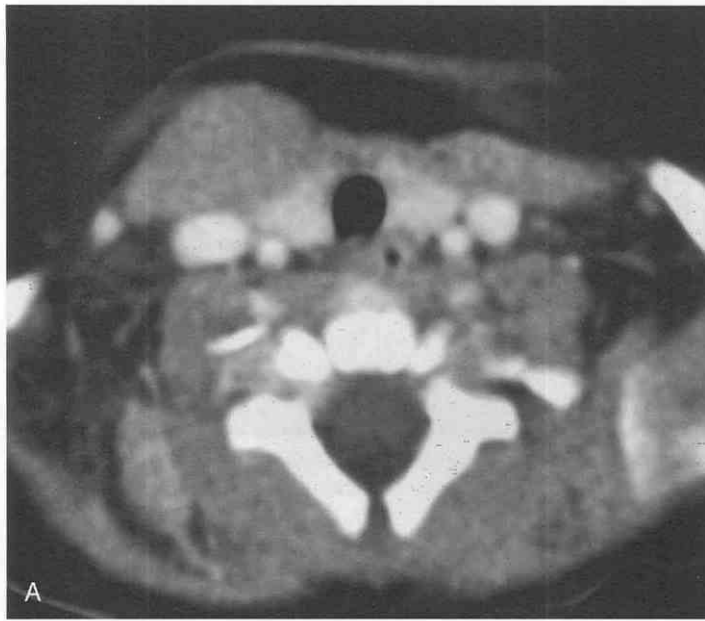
Fibromatosis colli. *A*, Axial postcontrast CT scan. There is marked asymmetry of the sternocleidomastoid muscles, with the larger muscle on the right. No abnormal enhancement is seen. *B*, Coronal T1-weighted MRI scan. The right sternocleidomastoid muscle is diffusely enlarged, with signal isointense to normal muscle (*curved arrows*).
